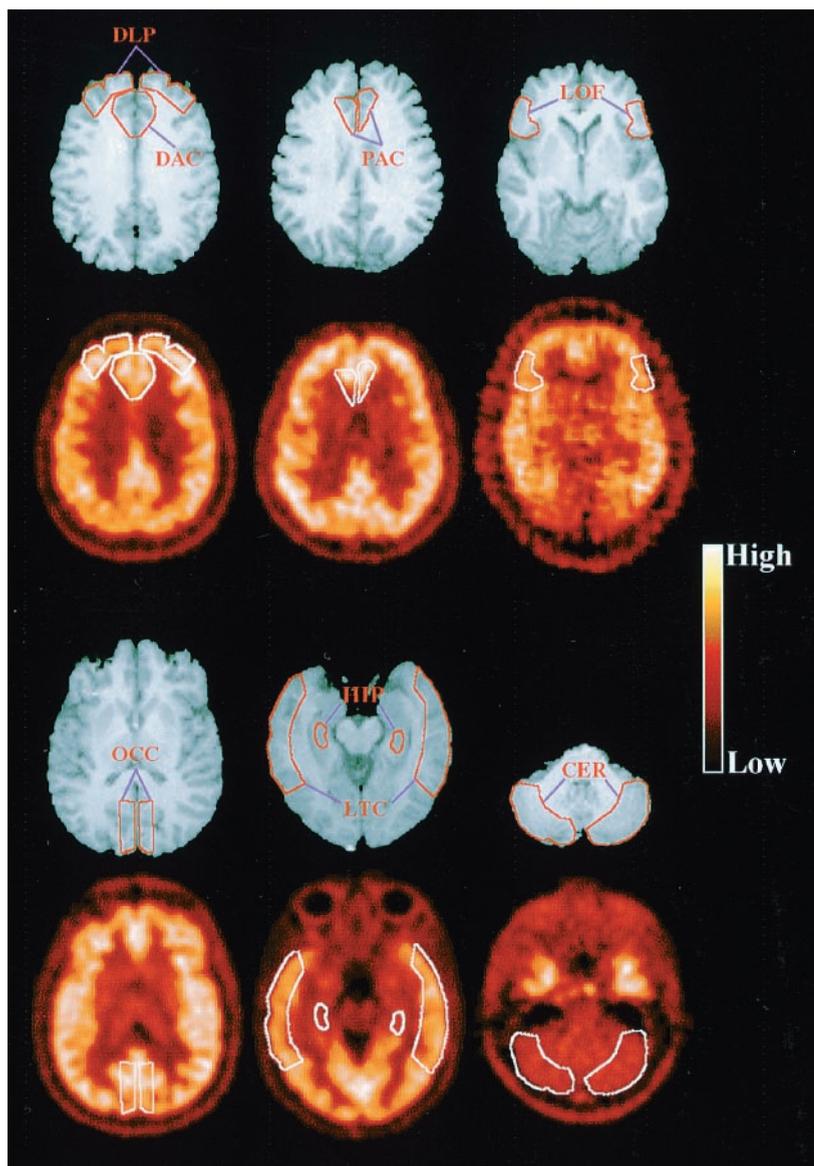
Representative horizontal magnetic resonance imaging sections through each of the regions of interest (ROIs; first and third rows). The coregistered baseline [ $^{18}\text{F}$ ]altanserin positron emission tomography (PET) scans for the same horizontal slices and subjects are shown below, in images generated post hoc by summing dynamic PET frames from 45 to 90 min. Color scale indicates radioactive counts per pixel. The dorsal anterior cingulate cortex (DAC) ROI was defined on the anterior cingulate gyri in the four planes situated immediately dorsal to the dorsum of the corpus callosum. The dorsolateral prefrontal cortex (DLP) ROI was defined on the middle and superior frontal gyri in three planes immediately dorsal to the dorsum of the corpus callosum. The pregenual anterior cingulate cortex (PAC) ROI was defined on the anterior cingulate cortex situated immediately rostral to the genu of the corpus callosum in three planes. The lateral orbitofrontal cortex (LOF) ROI was defined on the inferior frontal gyrus on one plane at the level of the third ventricle. The occipital cortex (OCC) was defined on the lingular and cuneate gyri at the level of the third ventricle. The lateral temporal cortex (LTC) ROI was defined on the middle temporal gyrus on one plane. The hippocampus (HIP) sampled the head of the hippocampus posterior to the alveus and temporal horn of the lateral ventricle in up to five planes and beyond  $2 \times$  full width half maximum from the insula, LTC, and fusiform gyrus. The cerebellar cortex (CER) ROI was defined on the CER at the level of the fourth ventricle (Talairach and Tournoux 1988).
